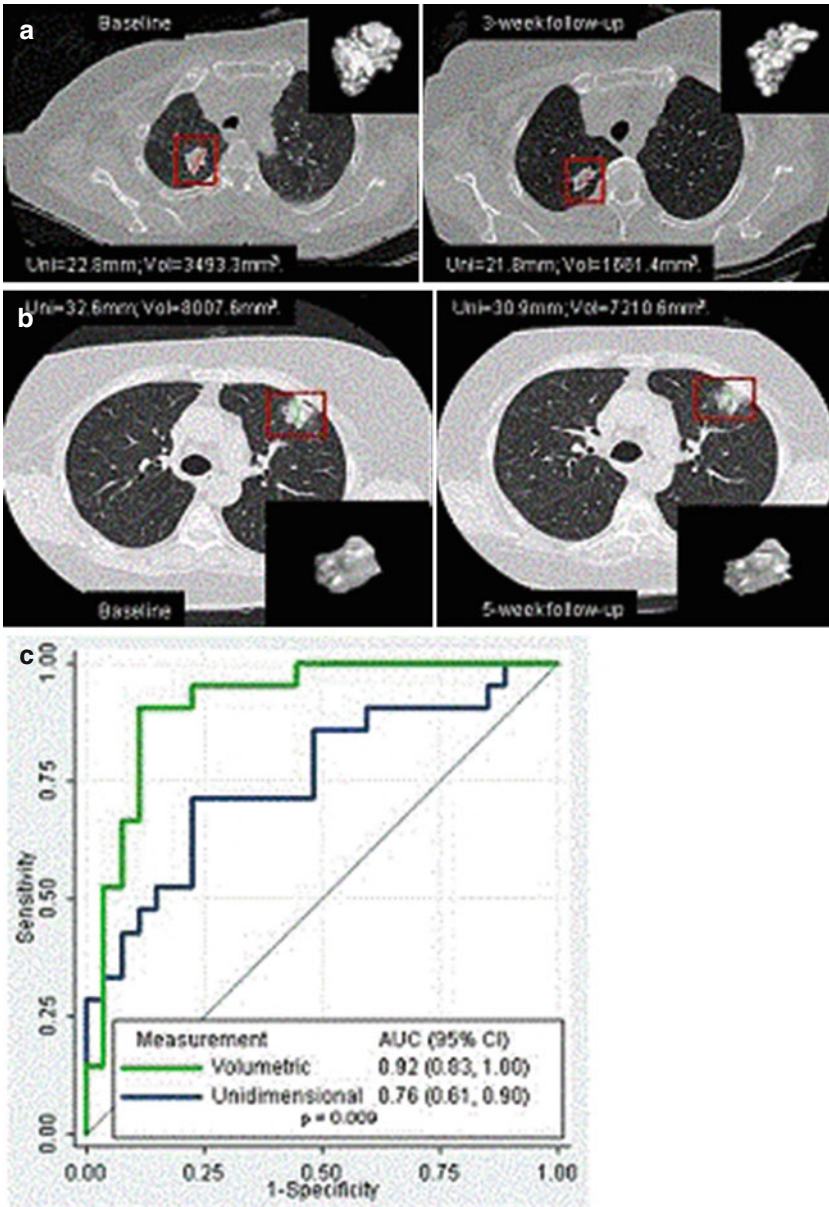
Volumetric CT technique in tissue biomarker discovery. (a) Shows an *EGFR* mutant NSCLC (likely response to gefitinib therapy). Changes in unidimensional and volume measurements were -4.4 and -52.4 %, respectively. The volumetric technique detected tumor change at 3 weeks post-therapy, whereas the diameter technique did not. (b) Shows a *KRAS* mutant NSCLC (resistant to gefitinib therapy). Changes in unidimensional and volume measurements were -5.2 and -10.0 %, respectively. Both measurement techniques showed no real tumor change at 3 weeks post-therapy. (c) Receiver operating characteristic curve (ROC) shows a significantly higher area under the curve (AUC) of the volumetric measurement than unidimensional measurement, indicating that early volumetric change is a better metric for predicting *EGFR* mutation status than is early diameter change (a, c): Used with permission from Zhao et al. [42]
